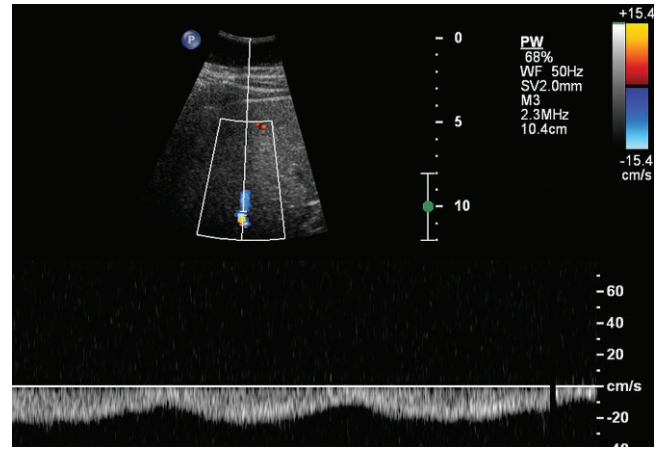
Spectral Doppler of middle hepatic vein in cirrhosis. The cardiac pulsatility seen in normal patients is absent. The waveform changes minimally indicating it is blunted. This can be seen in cirrhosis or if there is a venous obstruction between the sample volume and the heart (e.g., Budd Chiari syndrome). A deep inspiration can cause some blunting of the normal hepatic vein waveform but not to this extent.
